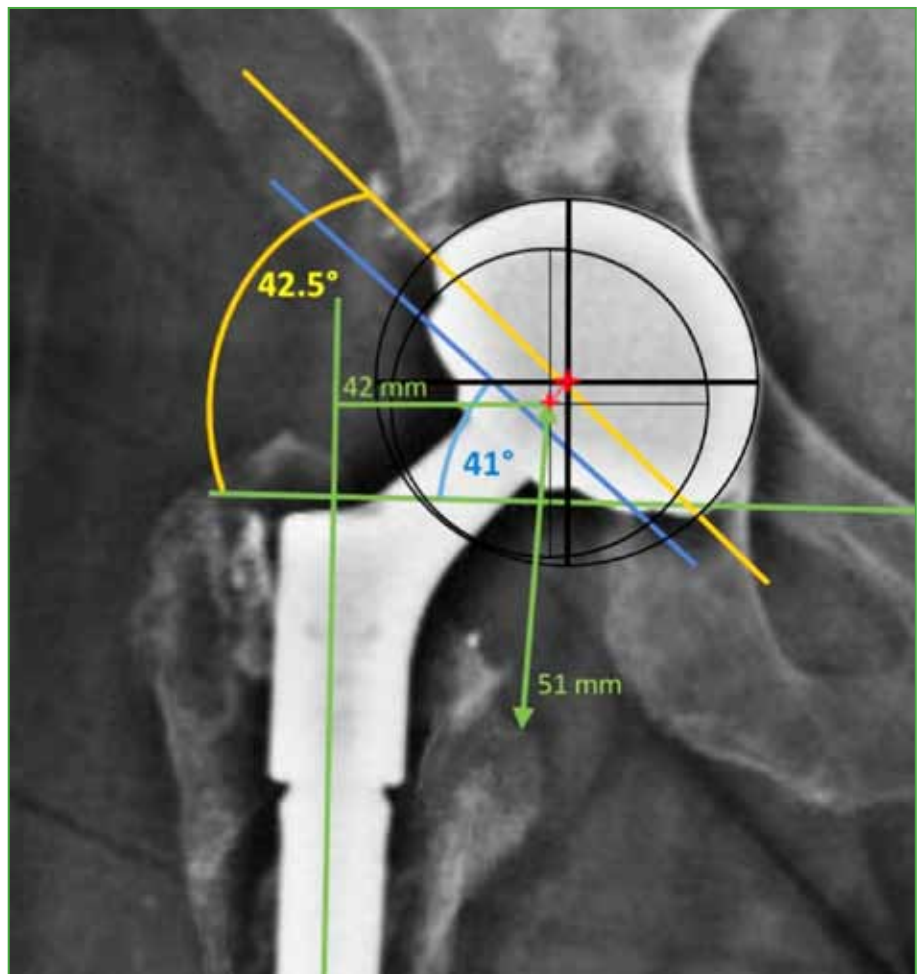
Radiographic evaluation 24 months after surgery.
